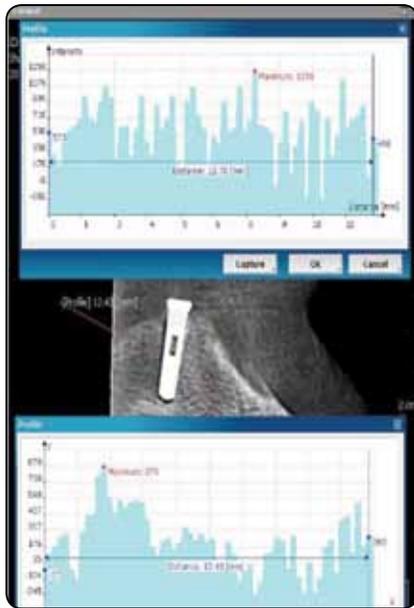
Assessment of bone density on CBCT.
